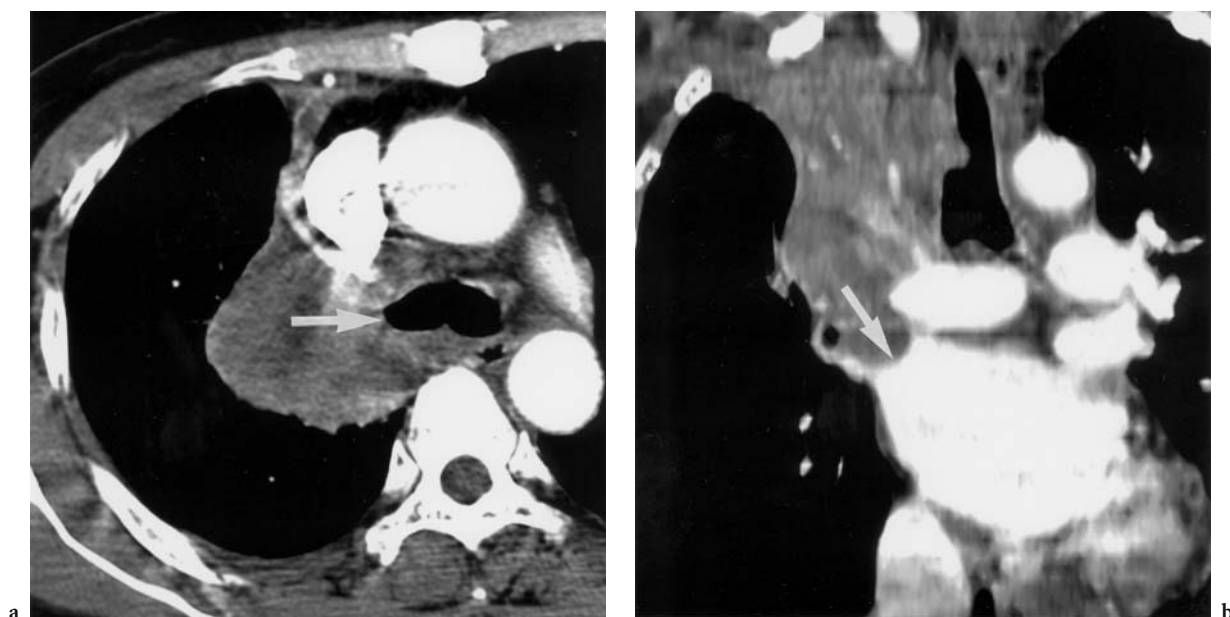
Invasion of left atrium. a. Axial CT image shows central lung cancer resulting in obstruction of right upper lobe bronchus (arrow). b. Coronal reformation image demonstrates invasion of superior aspect of left atrium (arrow) [Case courtesy of Dr. Kyung S. Lee, Samsung Medical Center, Seoul, Korea]
